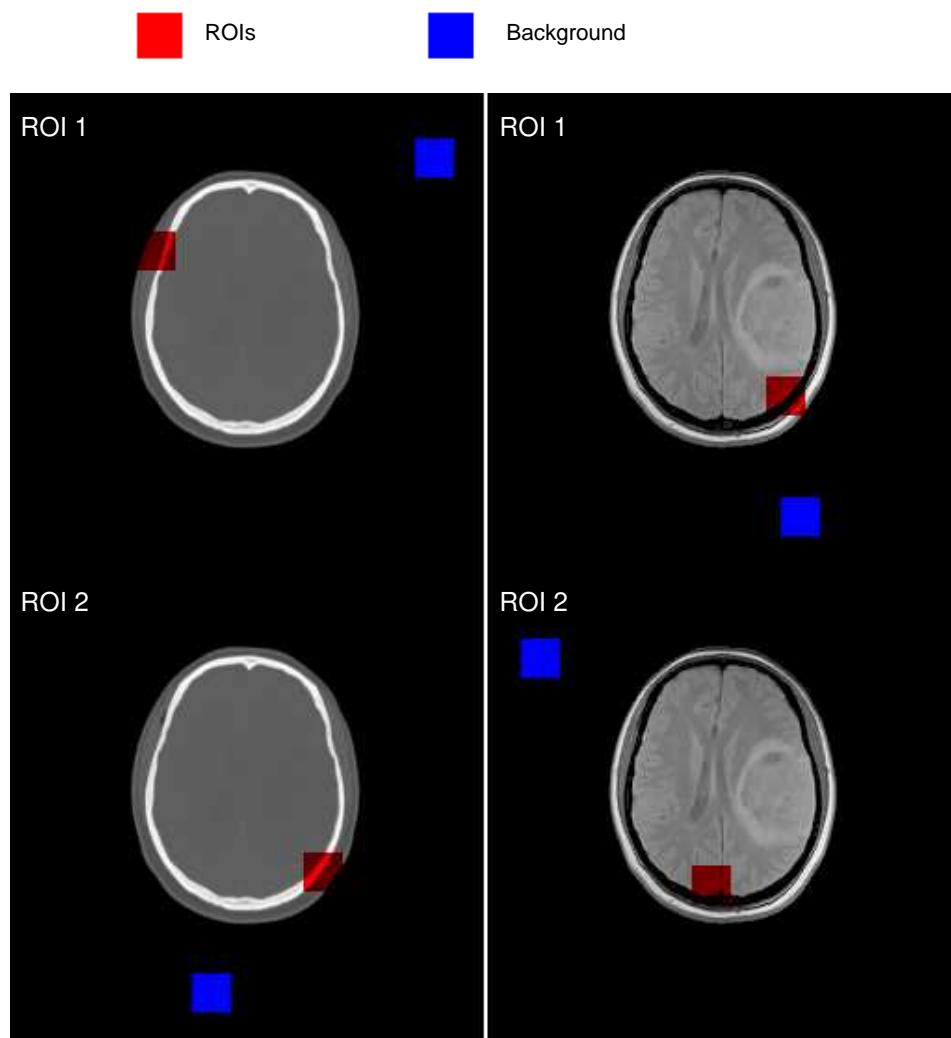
Two ROIs are chosen from both CT and MRI head images. ROIs are highlighted in red, whereas regions of background are also chosen, and are labeled in blue.
